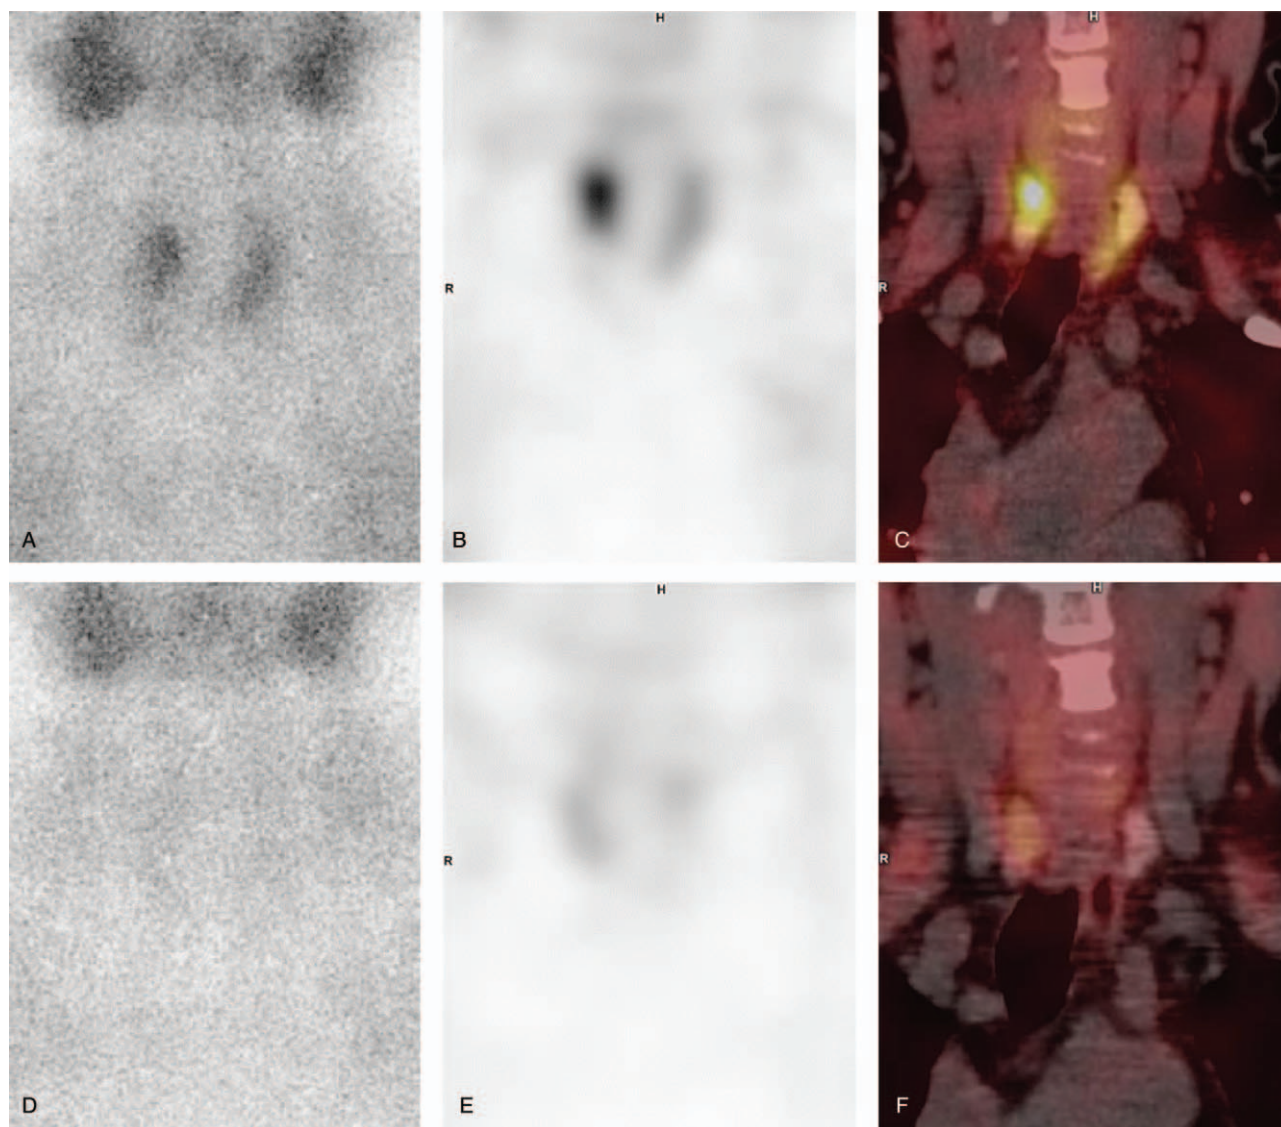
Parathyroid images (a: early planar, b: early SPECT, c: early SPECT/CT, d: delayed planar, e: delayed SPECT, f: delayed SPECT/CT) of a 34-year-old woman with primary hyperparathyroidism. A parathyroid adenoma (0.7 cm, 80 mg) was identified after the surgery. The lesion is considered to be positive in dual-phase SPECT, delayed SPECT/CT, and dual-phase SPECT/CT.
